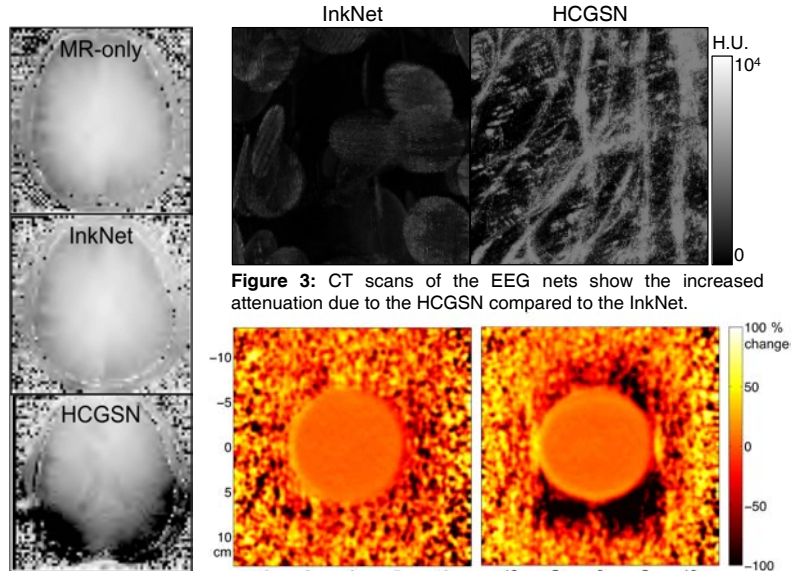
CT scans of the EEG nets show the increased attenuation due to the HCGSN compared to the InkNet.
